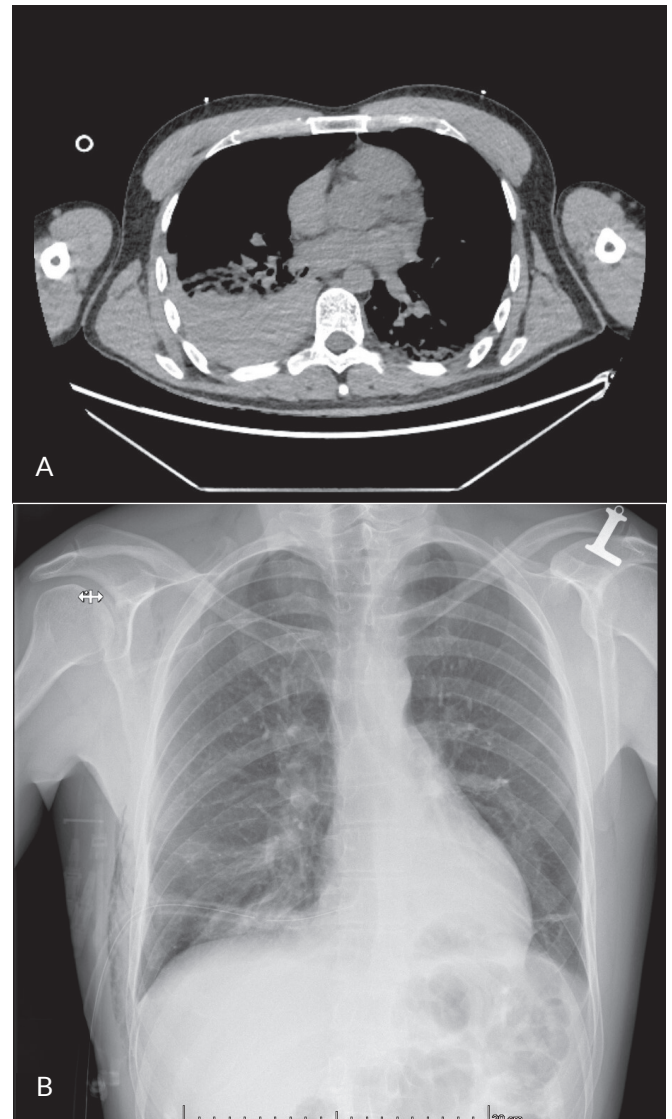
Case 6. A. Preoperative computed tomography. B. Postoperative x-ray
